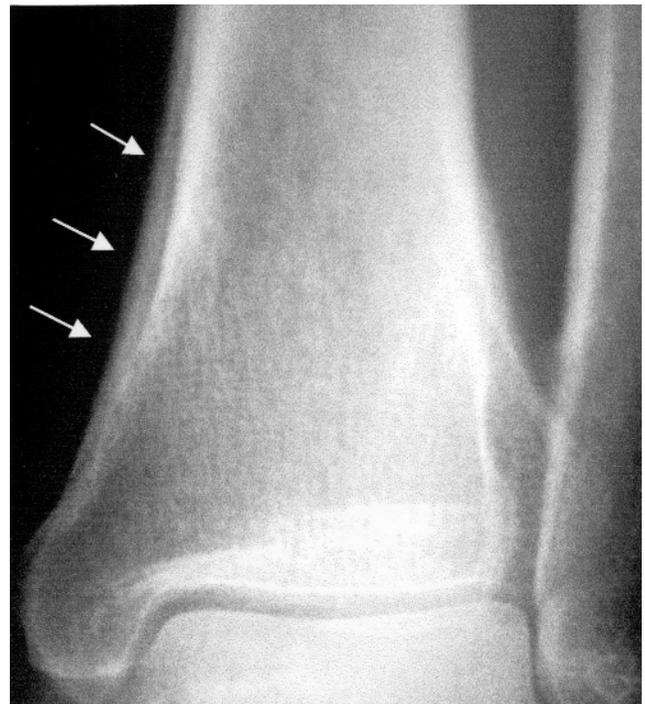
Radiographic anteroposterior view of the left ankle shows a radiolucent line beneath the periosteum.
